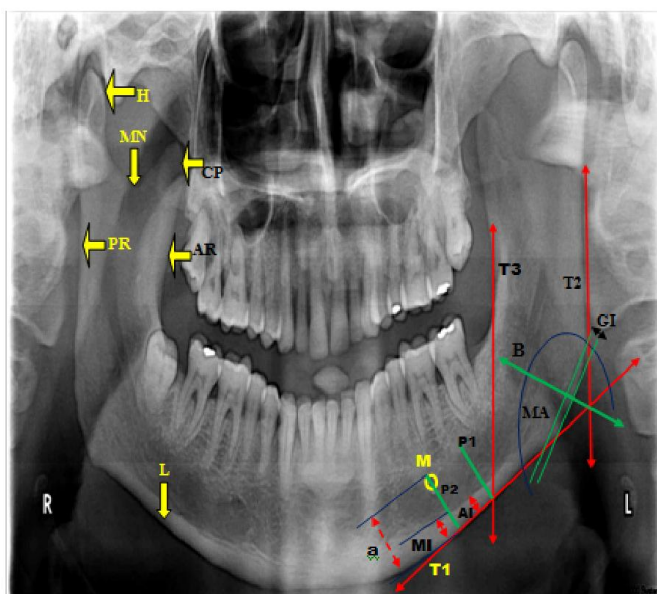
Measurement of mandibular radiomorphometric indices on an orthopantomograph
